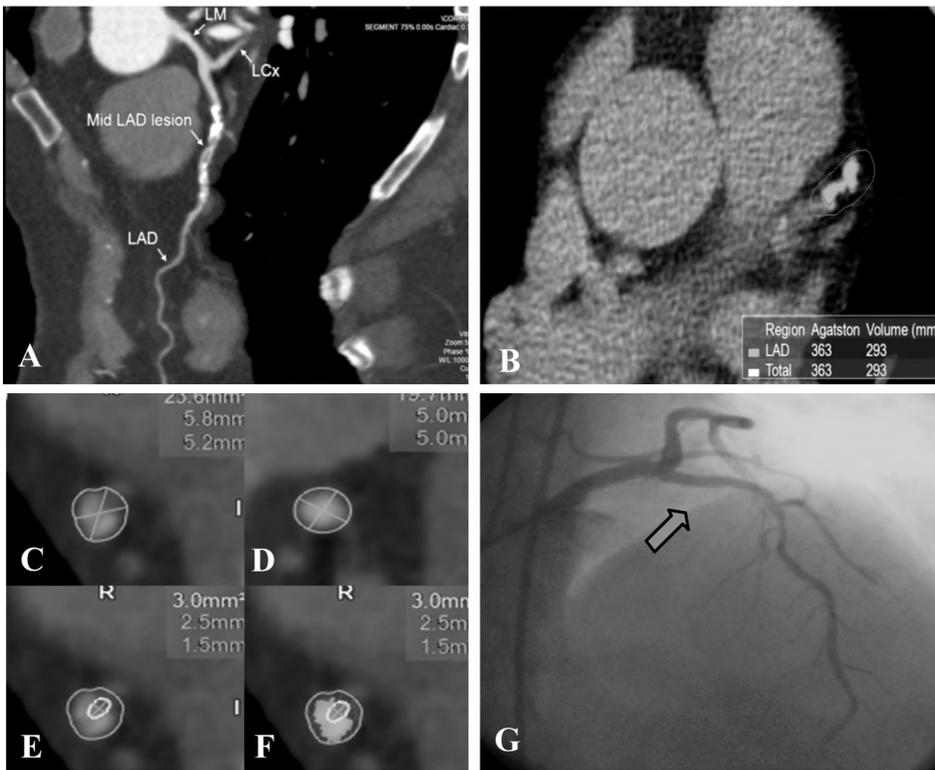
53-years old female patient, diabetic, hypertensive complaining of recurrent attacks of atypical chest pain (chest discomfort), and dypnea on exertion. Echocardiography revealed no regional wall motion abnormalities. (A) Curved multiplanar reformatted image showed moderate mid-LAD lesion exerted by mixed calcified and non calcified plaques. (B) Pre-contrast calcium volume was  $293\text{mm}^3$  (by Calcium score). Remodeling index was obtained from the ratio of lesion plaque area ( $23.6\text{mm}^2$ ) at (C) To referential area ( $19.7\text{mm}^2$ ) at (D), In the case represented= $1.20$ . (E) Cross sectional area at the site of maximal narrowing; inner circle represented luminal cross sectional area. (F) Application of color map at the site of maximal narrowing; yellow color represented calcium, blue color represented fibrous component and red color represented lipid component. (G) Invasive coronary angiography RAO CRA view showed moderate mid-LAD lesion.
